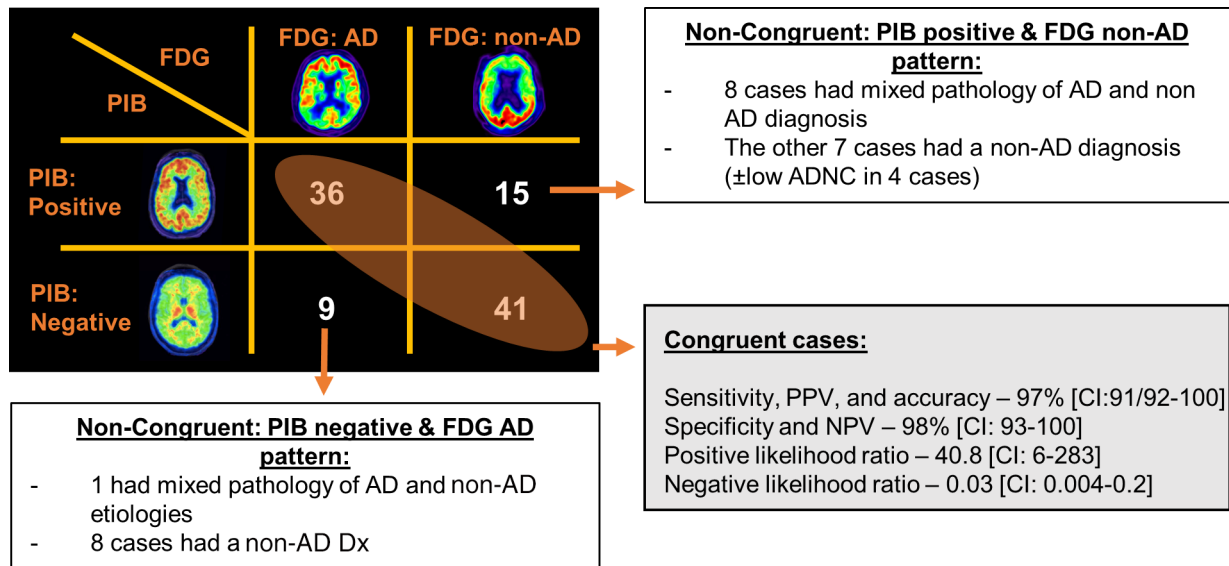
Agreement between  $^{11}\text{C}$ -Pittsburgh compound B (PIB) and  $^{18}\text{F}$ -fluorodeoxyglucose (FDG) reads. AD = Alzheimer disease; ADNC = AD neuropathologic change; CI = 95% confidence interval; Dx = diagnosis; NPV = negative predictive value; PPV = positive predictive value.
